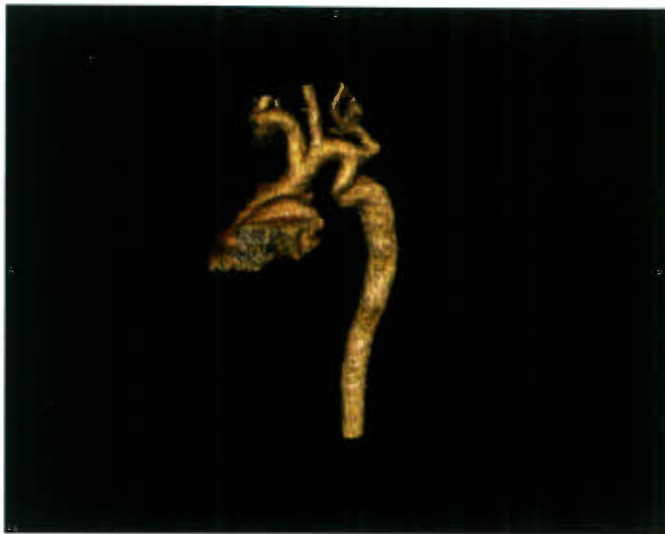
Three-dimensional reformatted CT angiogram in a left-lateral projection in a 19-month-old infant with a discrete coarctation and a tortuous, somewhat hypoplastic transverse arch and isthmus.
